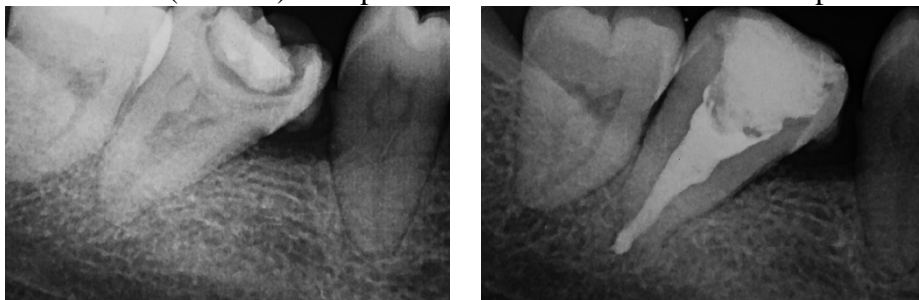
Tooth 47 with necrotic pulp. Control radiograph shows minimal over-filling and inadequate lateral condensation.
